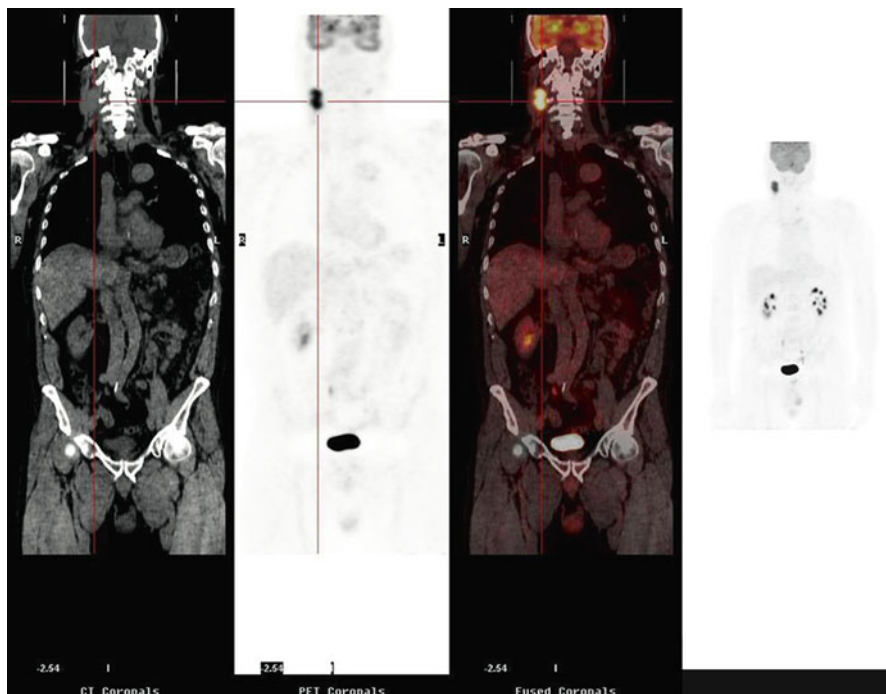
Head and neck tumor, 66 years old patient, ^{18}F -FDG study performed with PET/CT model *GE Discovery RX* (L. Menichetti, C.N.R. Institute of Clinical Physiology, Pisa, Italy) (Reprinted from Wittig et al. [2])
